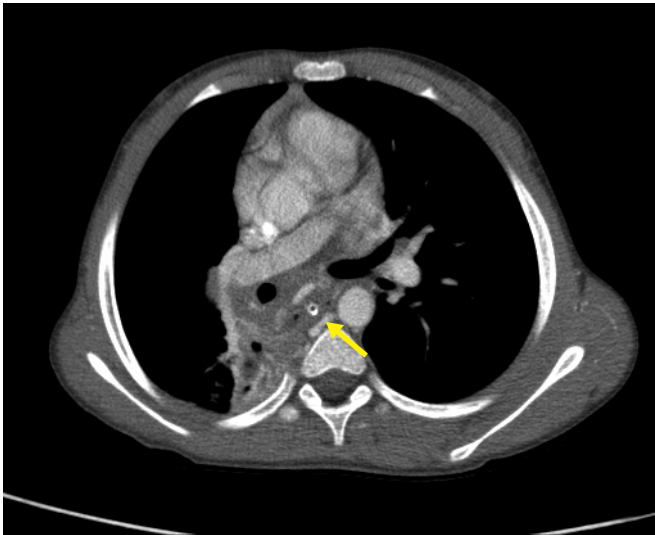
Computed tomography image demonstrating the complex vascular supply to the mass. Arrow indicates the branch of the aorta supplying the mass.
